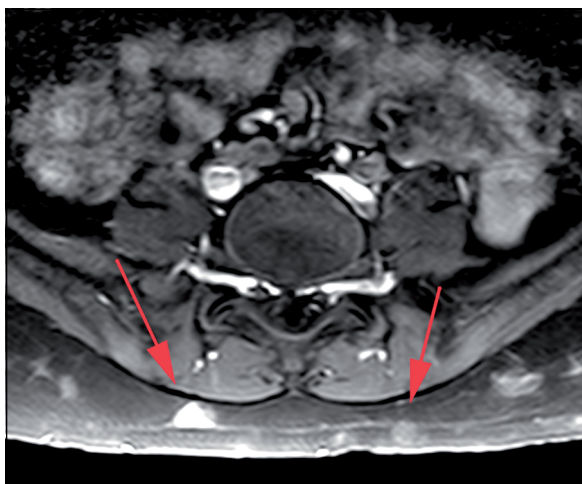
Lumbar spine MRI. Axial T1-weighted fat sat with Gd. Image showing subcutaneous nodules (red arrows).
